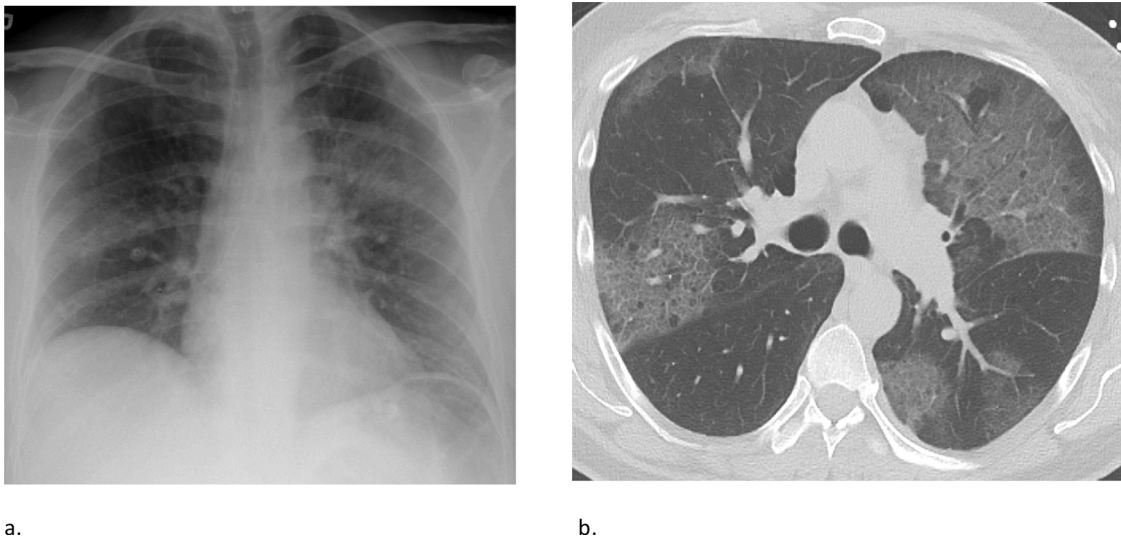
49 yo M with a history of smoking free-base crack cocaine, presenting with mental status changes and dyspnea. (a) PA CXR demonstrating faint patchy opacities in both lungs. (b) Chest CT in same patient demonstrating geographic areas of ground-glass opacity with associated interlobular septal thickening. The diagnosis of “crack lung”.
